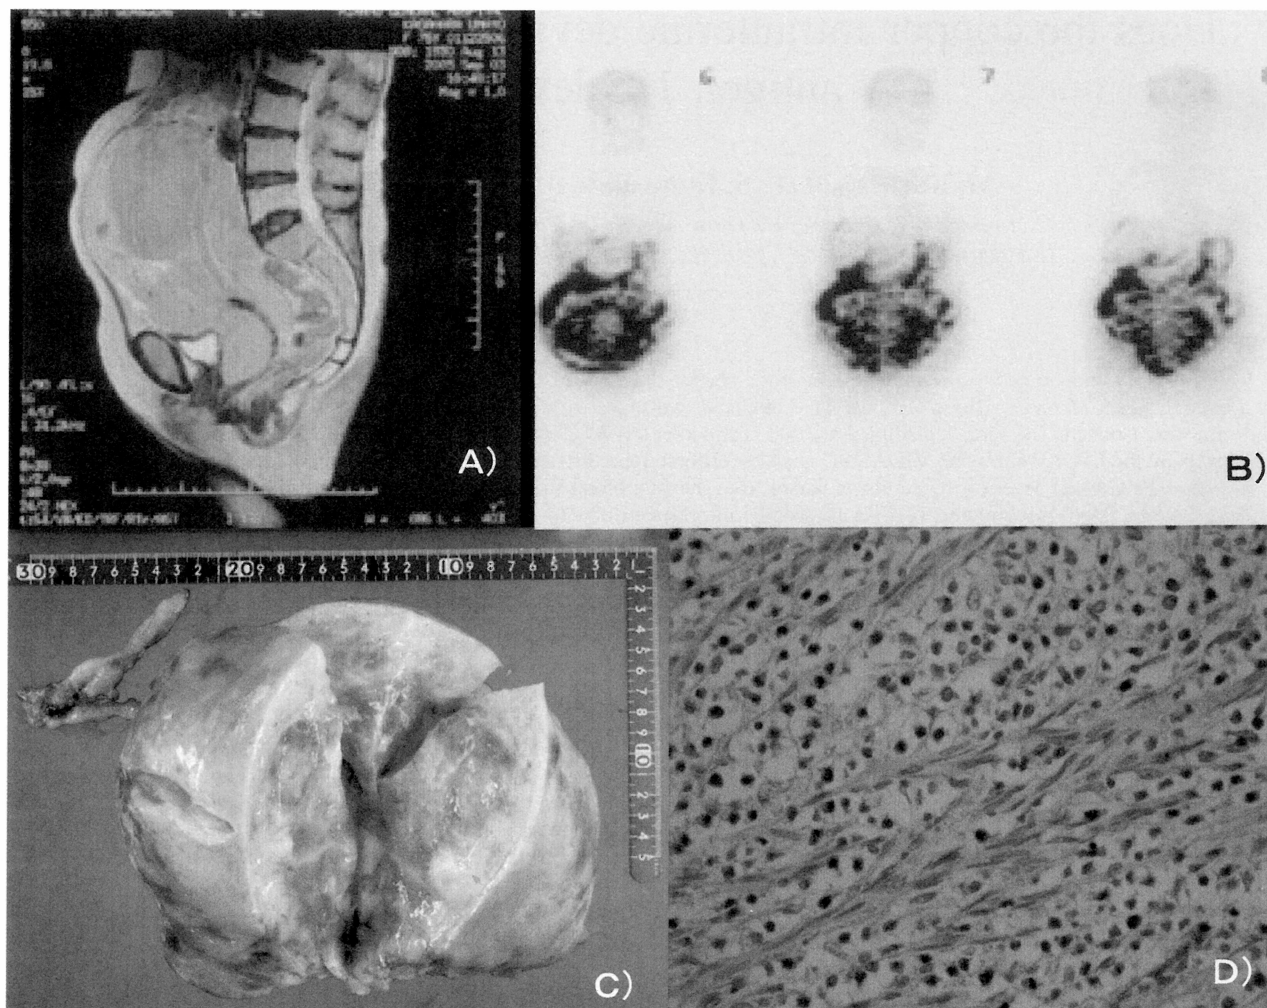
Pelvic MRI showing a huge enlarged mass, thus suggesting that it had arisen from the uterus.
